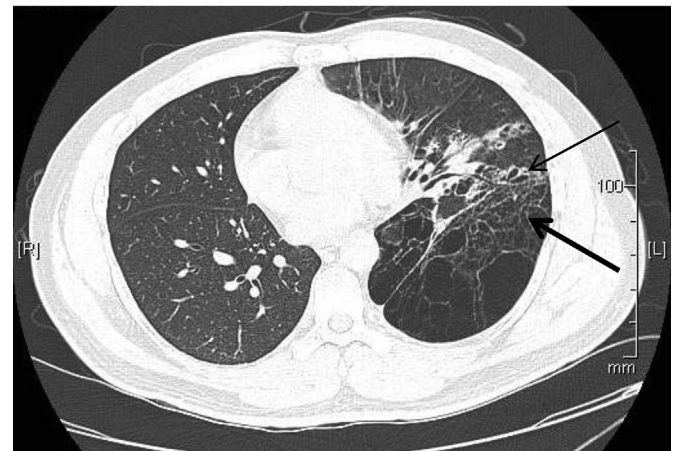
CT chest – large bullae in both left upper and lower lobes, with co-existing bronchiectasis (thin arrow) and cysts (bold arrow).
